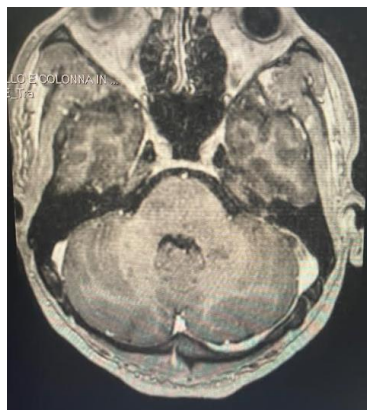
Axial MRI after intravenous contrast medium administration: there is no enhancement of the lesions.
